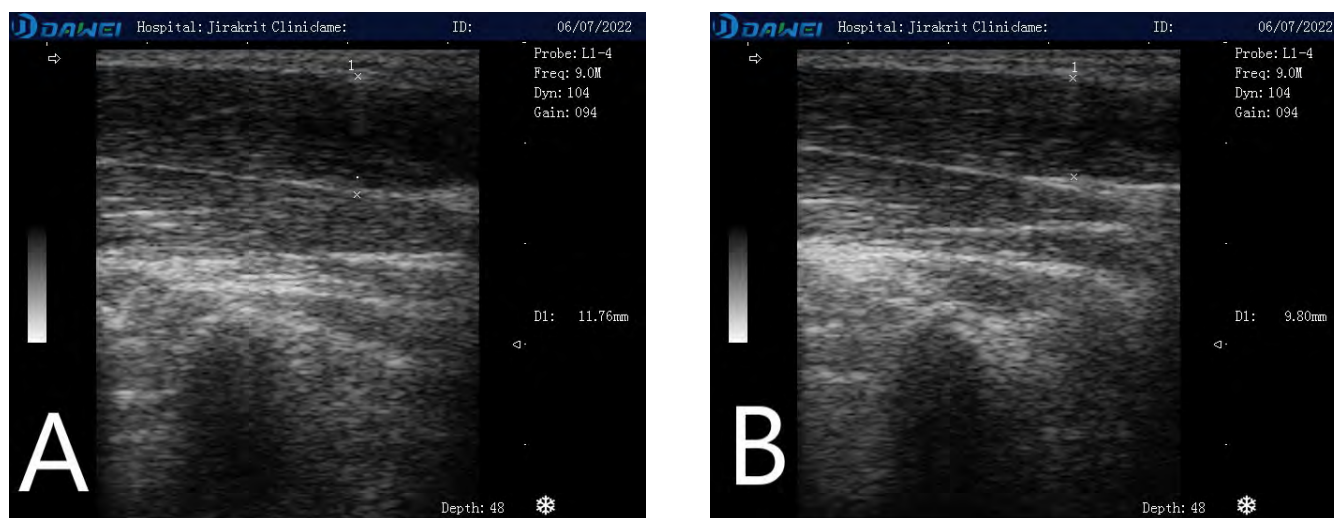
Ultrasonography image at 9 MHz, for measurement of upper trapezius muscle thickness before (A) and after completing the first intervention with Tok Sen (B). The vertical distance between two echogenic fascial layers was marked for measurement of upper trapezius thickness. D1 in both figures is a thickness of the upper trapezius muscle that was calculated by ultrasound imaging.
